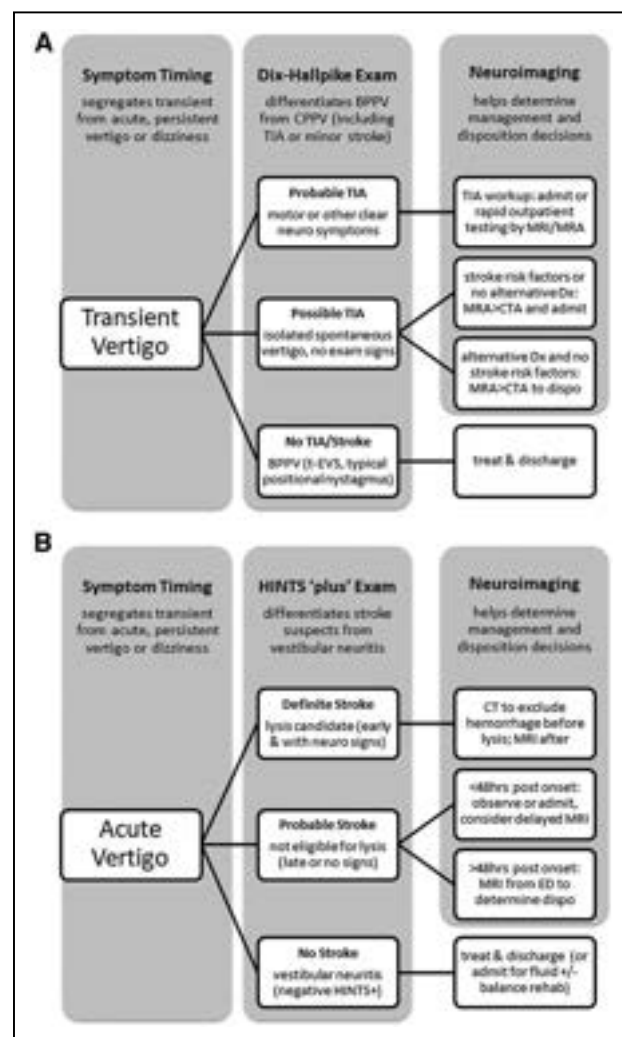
Suggested imaging strategy for stroke in patients with new (A) transient or (B) acute, continuous dizziness, or vertigo. Adapted from Newman-Toker et al¹² with permission. Copyright ©2017, Elsevier. BPPV indicates benign paroxysmal positional vertigo; CPPV, central paroxysmal positional vertigo; CTA, computed tomography angiography; Dx, diagnosis; ED, Emergency Department; HINTS, head impulse, nystagmus, test of skew; MRA, magnetic resonance angiography; MRI, magnetic resonance imaging; and TIA, transient ischemic attack.
